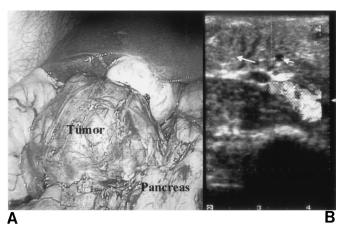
Intraoperative photo of the tumor located at the head of the pancreas (A) and the laparoscopic ultrasonographic appearance of the tumor as pointed out by big arrow and its relationship to the pancreatic duct as shown by the small arrow (B).
